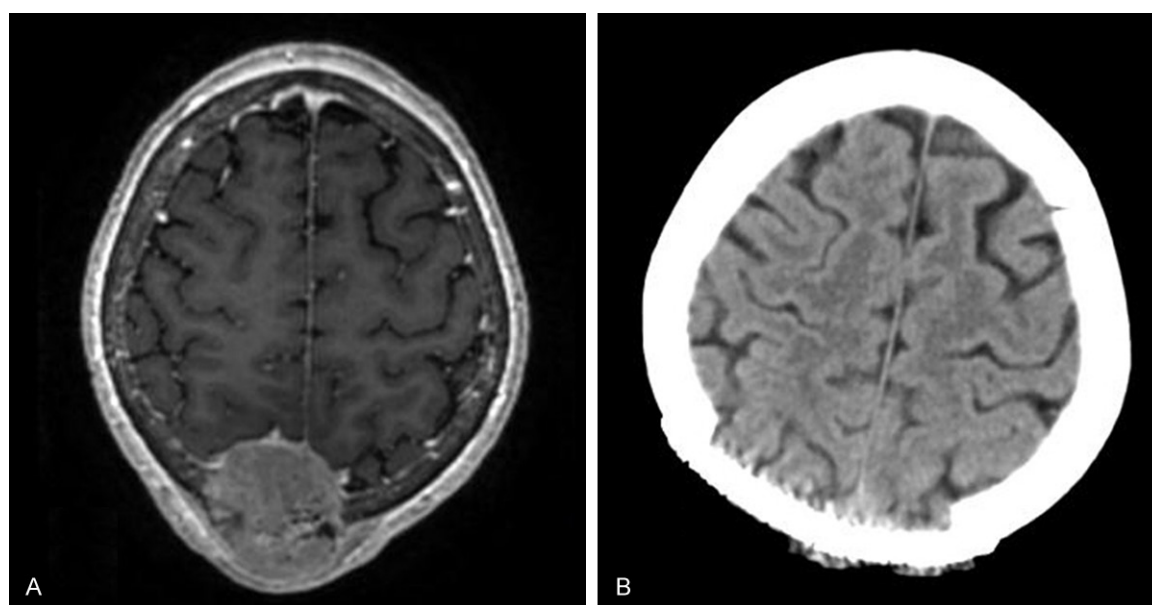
A. MRI demonstrated an extradural tumor with bone destruction and enhanced homogeneously by gadolinium. B. Postoperative CT of brain revealed the tumor was total resected and cranioplasty by digital shaping titanium mesh was performed.
